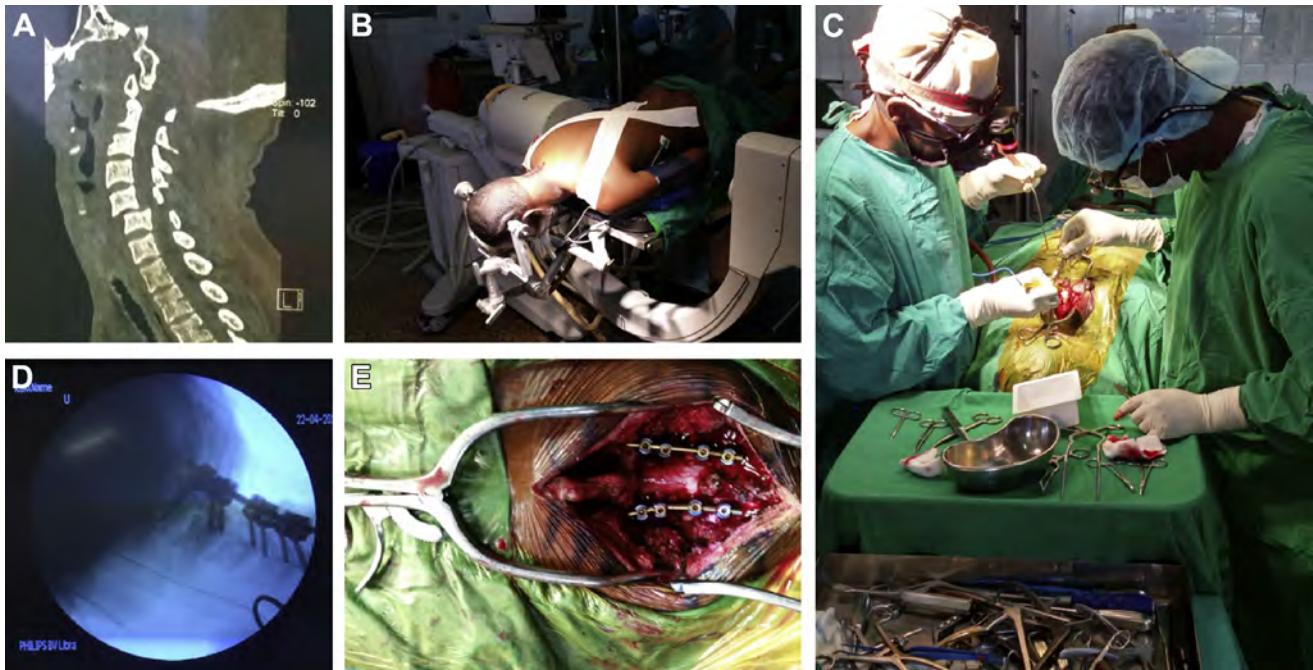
Patient with traumatic spondylolisthesis and incomplete spinal cord injury at C5-C6 after a motor vehicle crash in rural Tanzania. (A) Preoperative computed tomography. (B) Patient in prone position with head fixed in a Mayfield clamp for planned posterior decompression and instrumented fusion. (C) Intraoperative situation with 2 local surgeons
